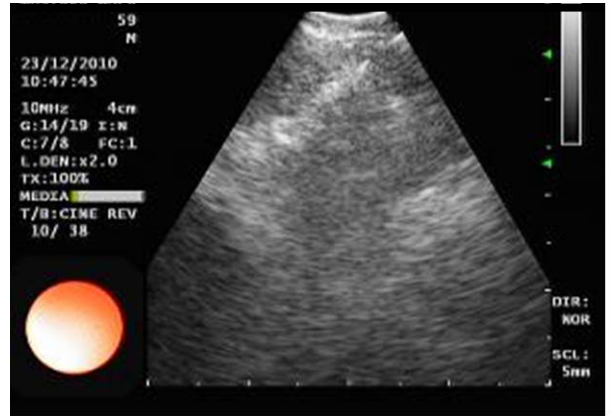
An endobronchial ultrasound image of anthracotic lymph node with indistinct margin and heterogeneous echogenicity in the subcarinal area.
